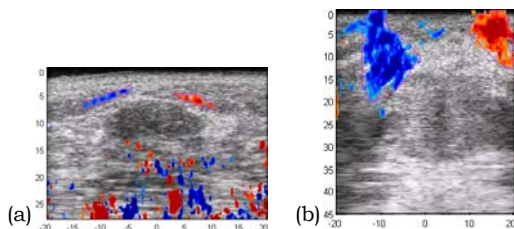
Examples showing the axial-shear strain region of interest as a color-overlay on top of corresponding sonogram of (a) fibroadenoma and (b) cancer. Notice that the axial-shear strain area (outlined for convenience) due to the cancer were bulkier compared to the slim ones due to the fibroadenoma.
